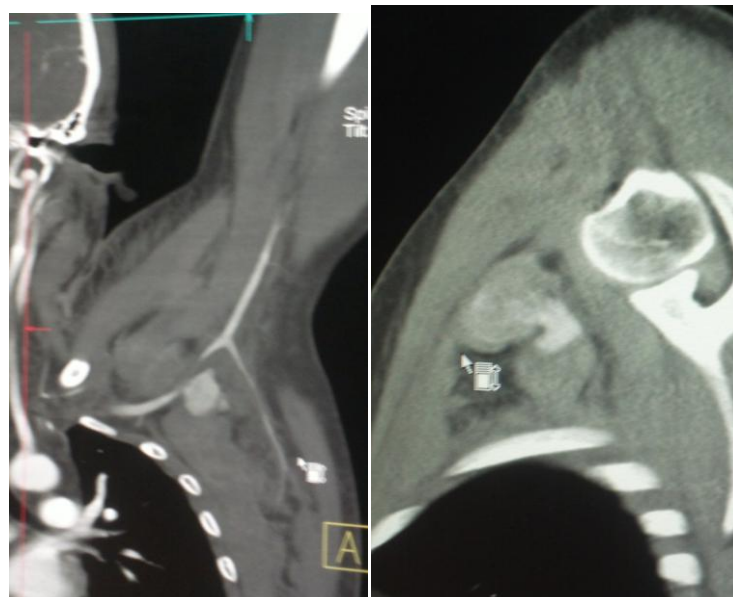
CT angiography showing subclavicular pseudoaneurysm with two openings in subclavicular artery anterior and posterior.
